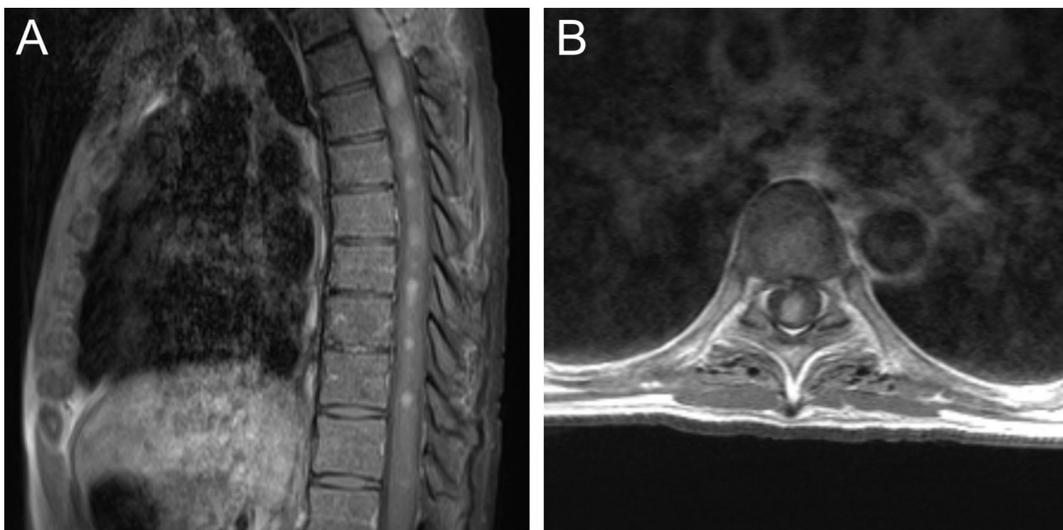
51 year-old male with a past medical history of HIV with MR imaging demonstrated an enlarging thoracic lesion and additional smaller lesions in his spinal cord (a and b).
